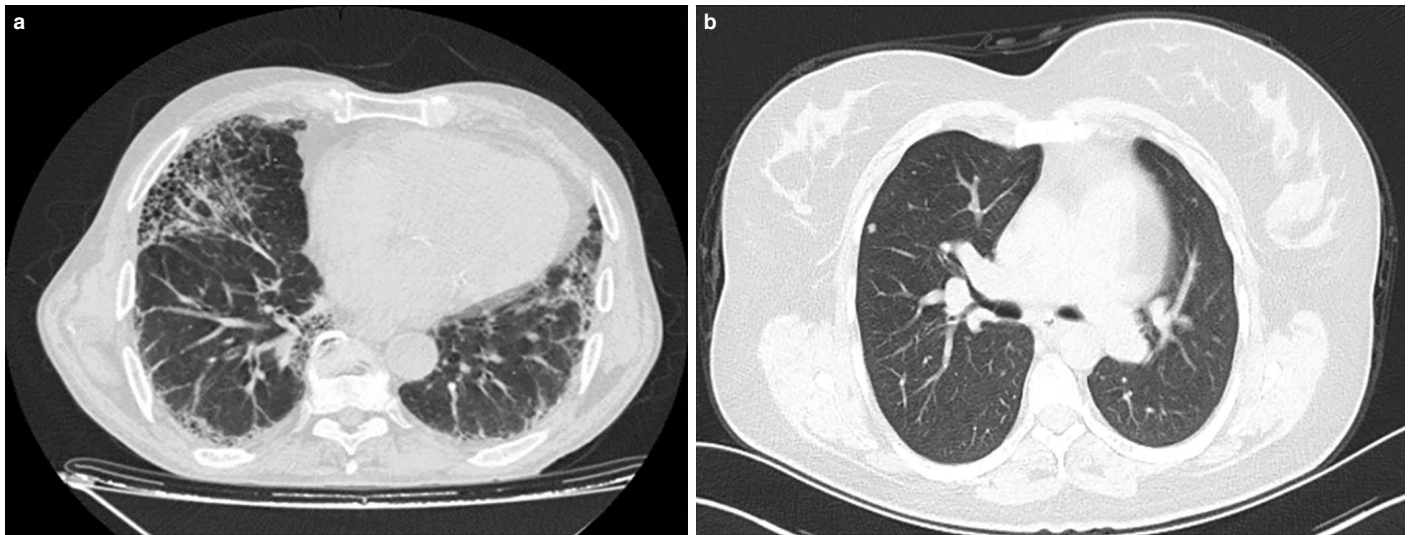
(a, b): An axial HRCT image of our 71-year-old nonsmoker male patient with RA show honeycombing in the bilateral lower lobes. An axial HRCT image of our 47-year-old female patient with RA shows a rheumatoid pulmonary nodule with 6 mm diameter located in the periphery of the right upper lobe anterior segment.
